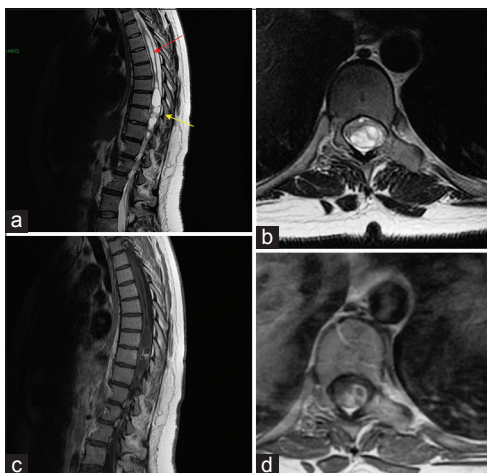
Spinal magnetic resonance imaging. (a) T2-weighted sagittal sequences showing the intramedullary lesion at T8–T9 level (yellow arrow), with solid (hypointense) and cystic (hyperintense) components. The cranial syrinx is evident (red arrow). (b) T2-weighted axial sequences demonstrating that the tumor is mainly located on the left spinal cord. (c) T1-weighted sagittal and (d) axial after gadolinium administration sequences showing the dishomogeneous contrast enhancement of the lesion
